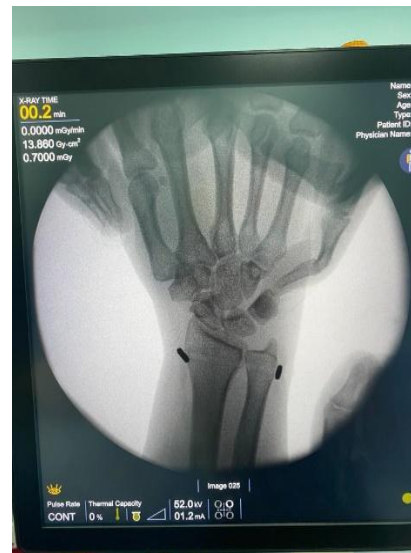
Pre-operative X-ray of left wrist.
